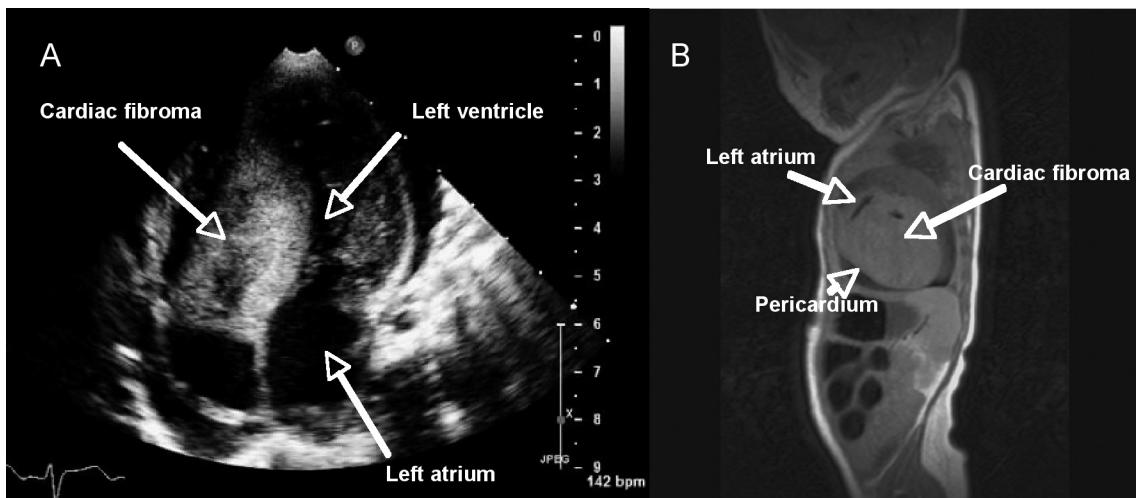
Cardiac fibroma in a 4-chamber echocardiography evaluation (A) and slightly hyperintense in T2-weighted magnetic resonance images (B).
